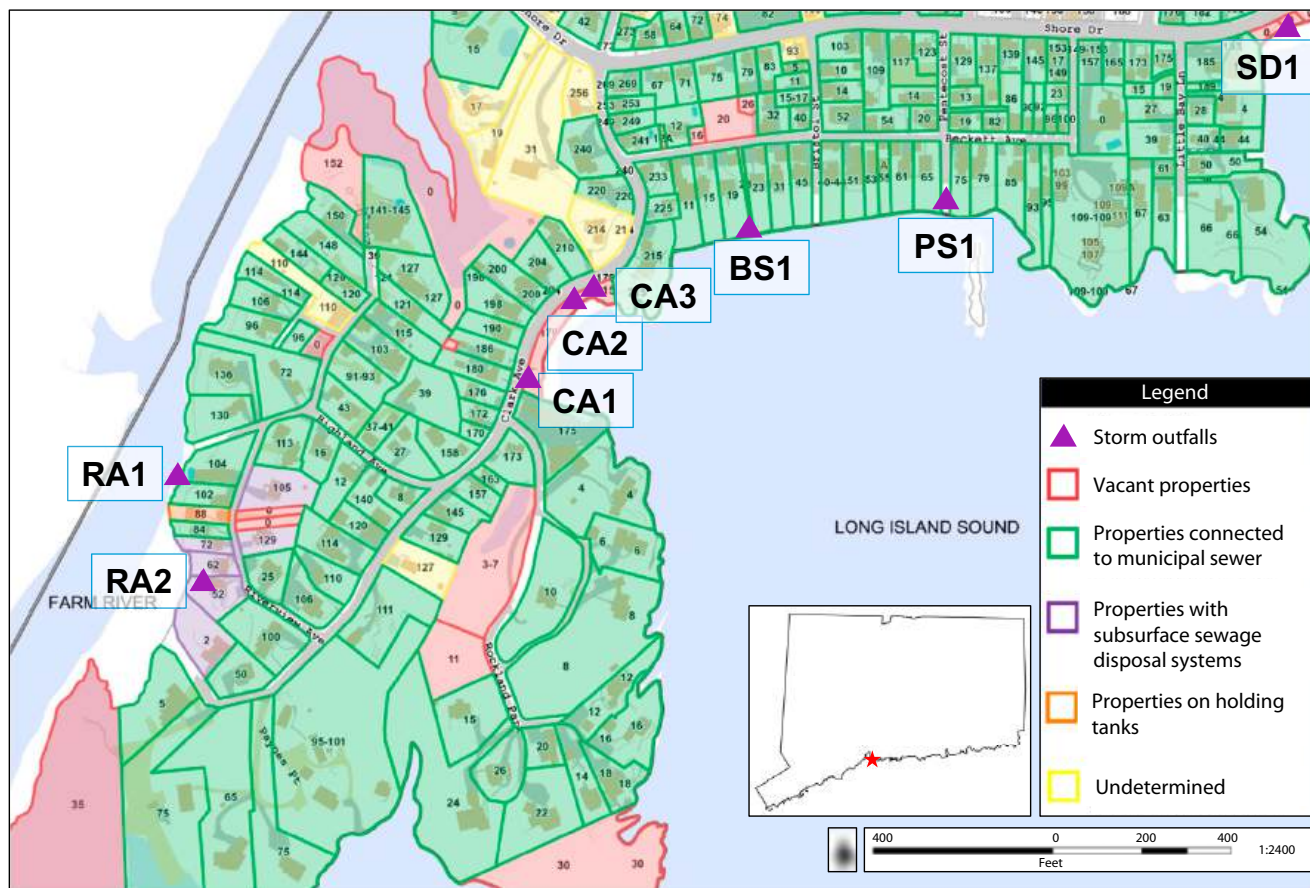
Map of Short Beach Neighborhood: Branford, CT, 2019
